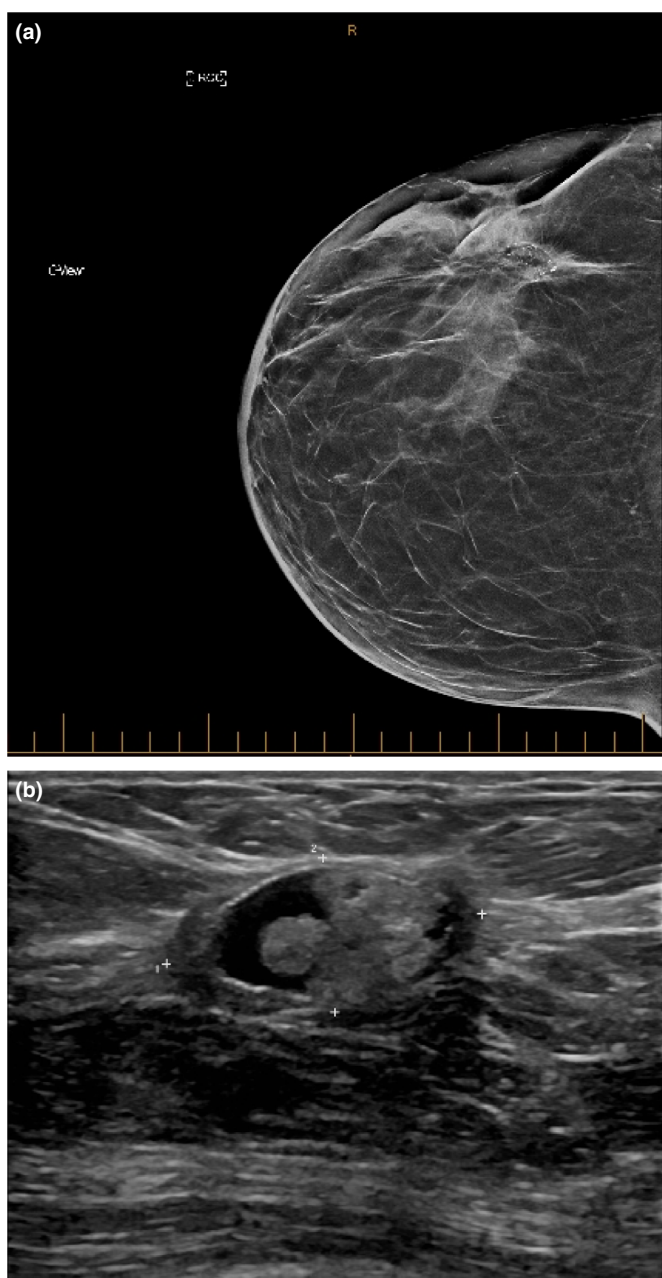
(a) Mammogram Showing Fat Necrosis and Oil Cyst Formation Following Lumpectomy and Radiotherapy Treatments Lateral Right Breast for Early Breast Cancer. (b) Ultrasound of Same Patient as (a) Demonstrating Oil Cyst with Calcification in Wall and Associated Necrotic Fatty Tissue.
